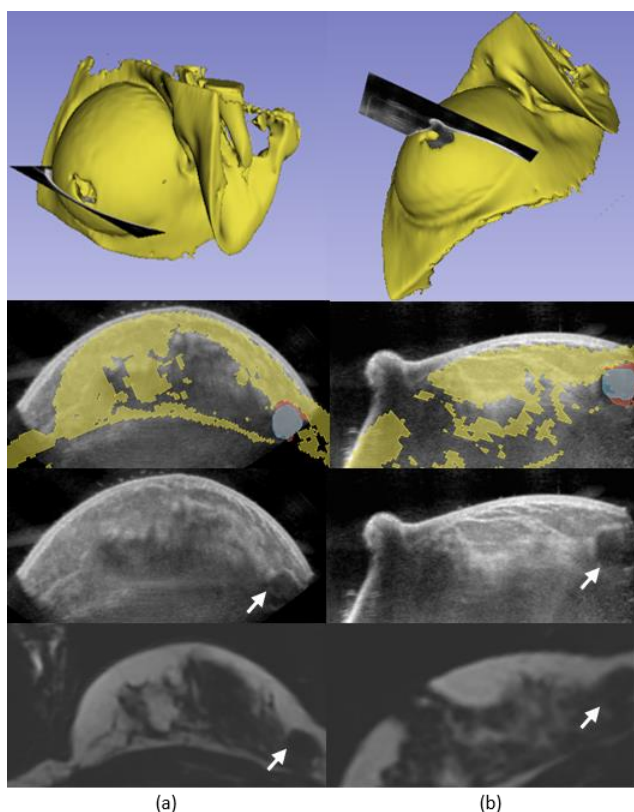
Simultaneous display of MRI and ACBUS data in (a) Cartesian view and (b) Radial view. From bottom to top: MRI cross-sectional data, ACBUS cross-sectional data, the cross-sectional image of MRI data superimposed on the ACBUS data (fibroadenoma segmented in MRI is indicated with red while the fibroadenoma segmented in US is indicated with blue), and finally the rendered MRI data with an US plane. The white arrows point at the fibroadenoma.
